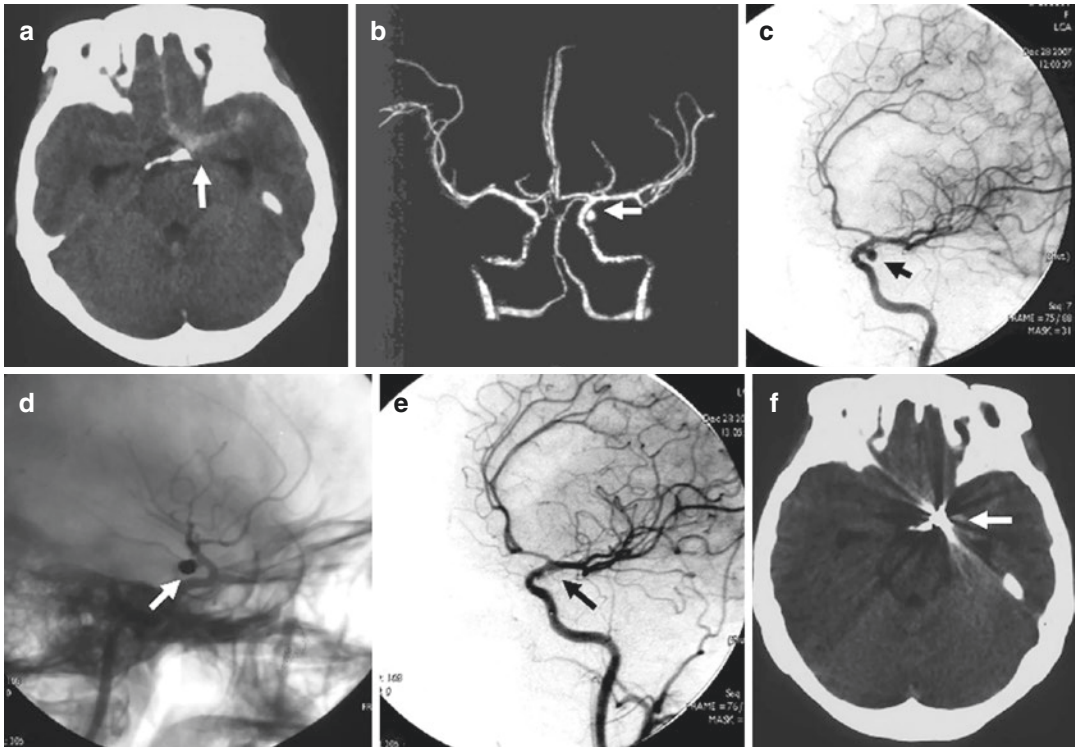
A 38-year-old woman with a ruptured posterior communicating artery aneurysm was coiled. (a) Cranial CT scanning showing subarachnoid hemorrhage of the suprasellar cistern (arrow). (b) CT angiography. (c) Oblique view of the left internal carotid artery injection. Showing the aneurysm of the left posterior communicating artery (arrows). (d) Lateral view of the unsubtracted
